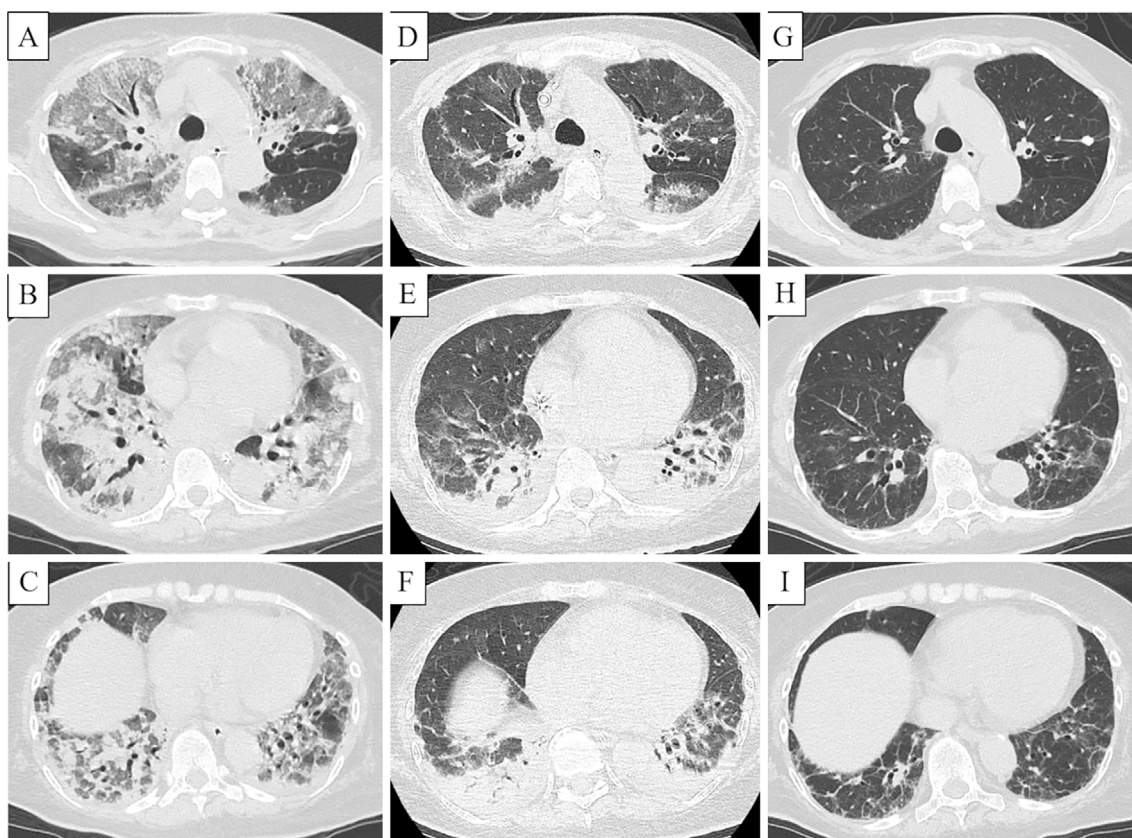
Computed tomography (CT) shows diffuse ground-glass opacities (GGOs) and consolidation in both lungs on the second day of hospitalization (A-C). CT shows that the GGOs in both upper lobes and consolidation in both lower lobes were reduced on the eighth day of hospitalization (D-F). Chest CT shows residual reticular shadows in both lower lobes on the 39th day of hospitalization (G-I).
